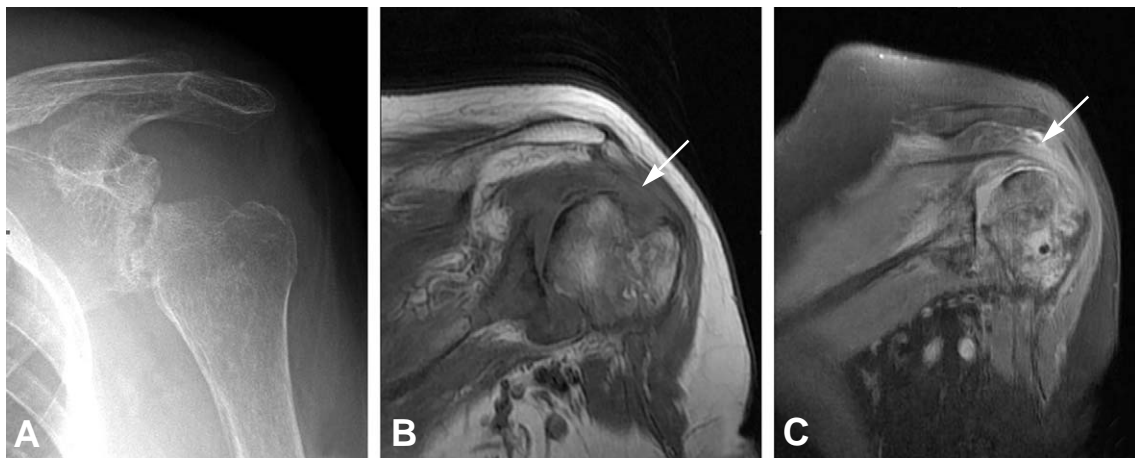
Preoperative simple radiogram (A) and magnetic resonance image (B), (C) revealing destruction of glenohumeral joint and supraspinatus tendon (arrow) in T1 and T2 weighted image respectively.
